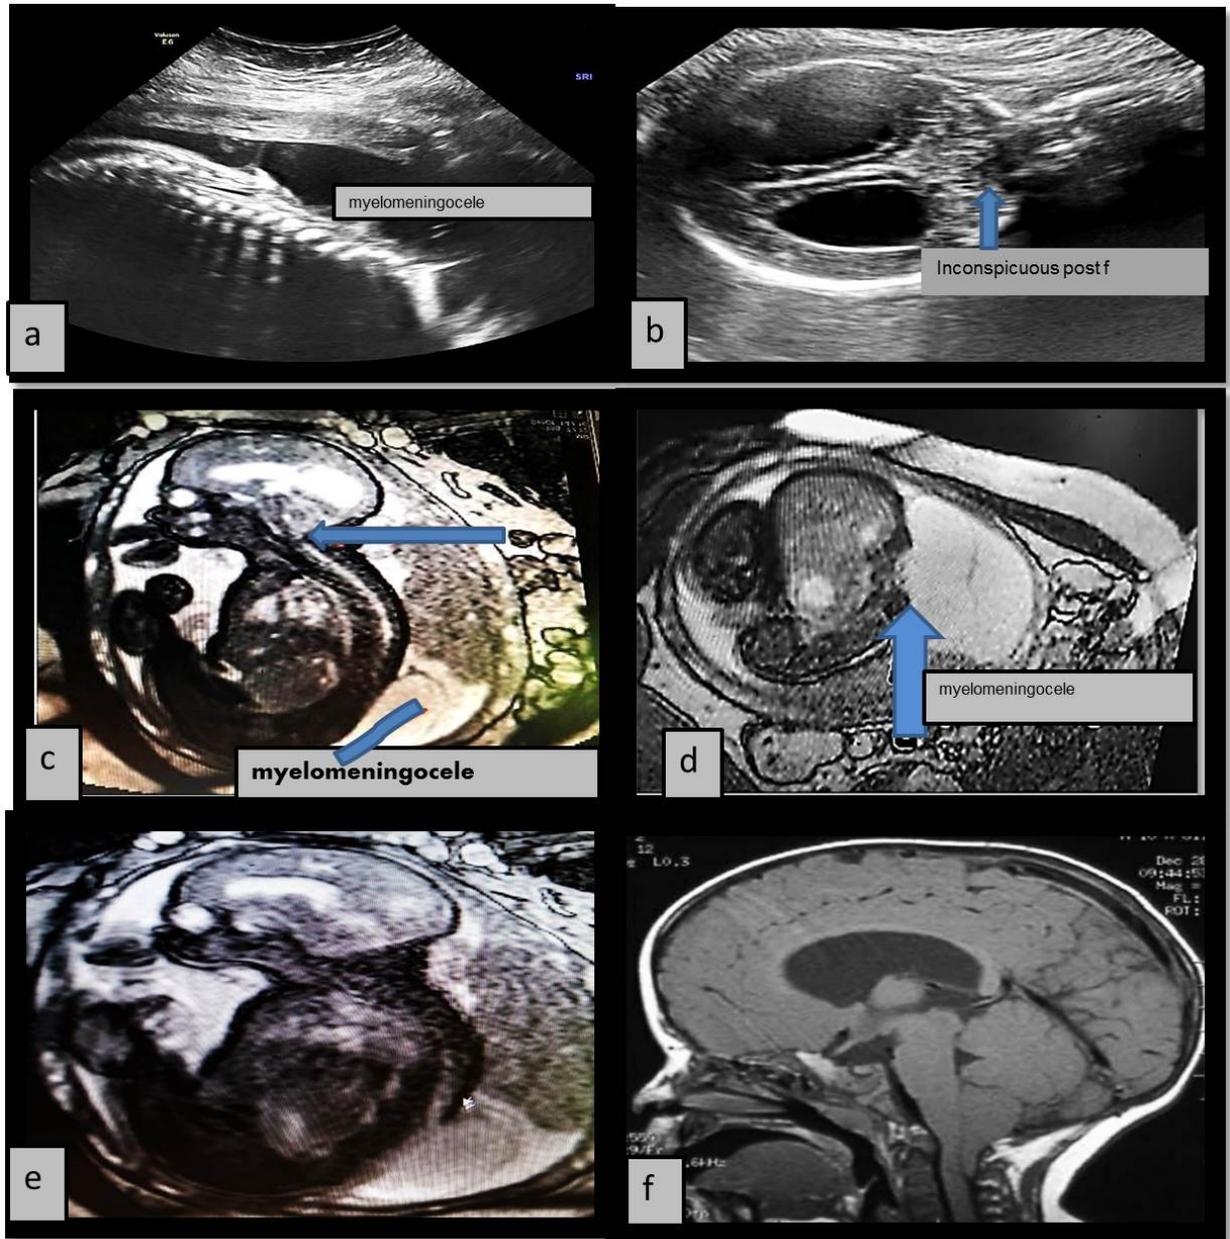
Fetus 32 weeks GA (a) Sagittal U.S image shows myelomeningocele at the distal spine.(b) Coronal U.S image shows moderately dilated ventricles with inconspicuous posterior fossa suggesting Chiari II. (c),(d) and (e) MRI T2WI in sagittal and axial planes confirmed U.S findings with adding the degree of cerebellar tonsil herniation and the corpus callosal dysgenesis (d) is a postnatal MRI, showing the same findings as the fetal MRI.
